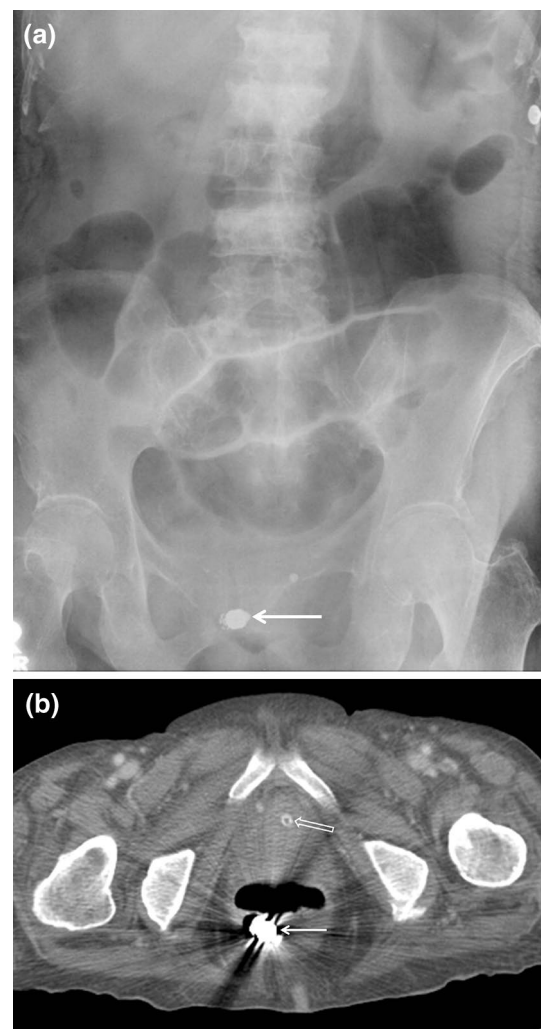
Retention of an endoscopic capsule in an 81-year-old female with chronic renal disease who had recent melena. a Abdominal radiograph obtained 25 days after capsule ingestion shows a retained capsule (*arrow*) in the lower pelvic cavity, suggestive of the rectum. b Subsequent CT scan demonstrates the capsule (*arrow*) within the rectum and a surrounding beam-hardening artifact. Note the inserted Foley catheter (*open arrow*)
